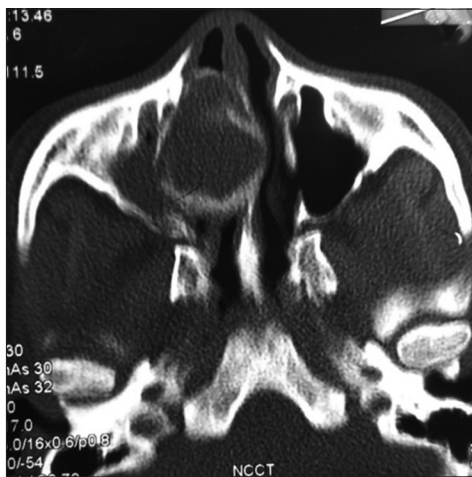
Computed tomography finding of a nasal mass showing peripheral calcification
